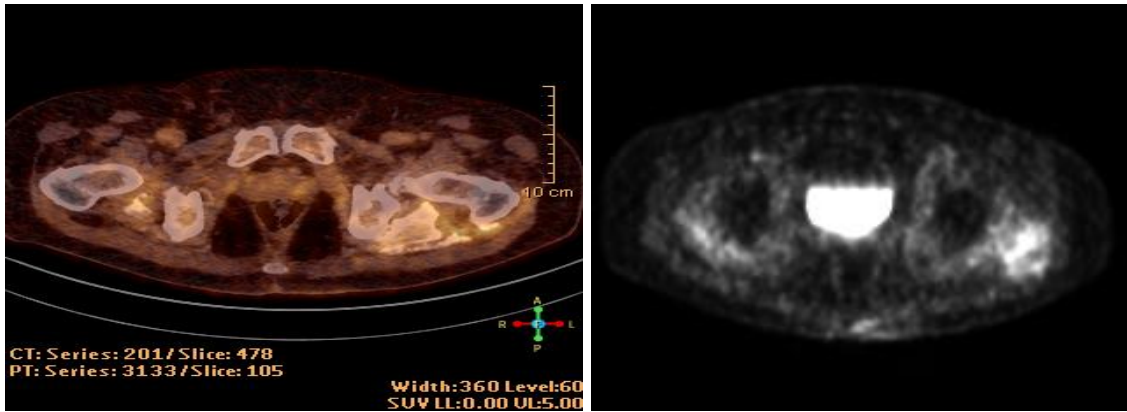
On the left is a tomographic transverse section of the pelvis fused with positron emission tomography (PET) and computed tomography (CT) images or PET-CT of the hip demonstrating increased accumulation of fluorodeoxyglucose in both hip joints with a maximum standardized uptake value of 4.6. On the right is a PET scan of both hips demonstrating early heterotopic ossifications in surrounding pelvic muscles. The imaging was obtained on 01. 03. 2021.
